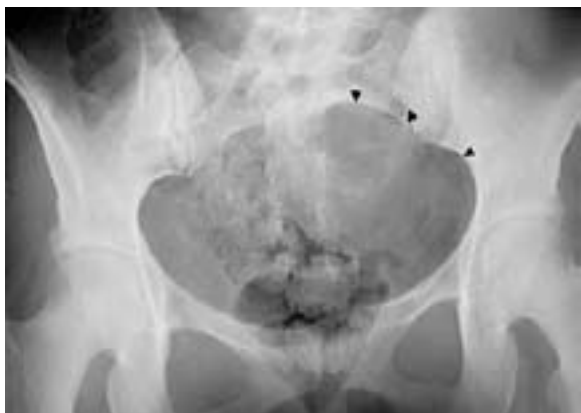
Plain anteroposterior pelvic radiograph demonstrating a large asymmetrical lytic lesion of the left sacrum (arrowheads).
